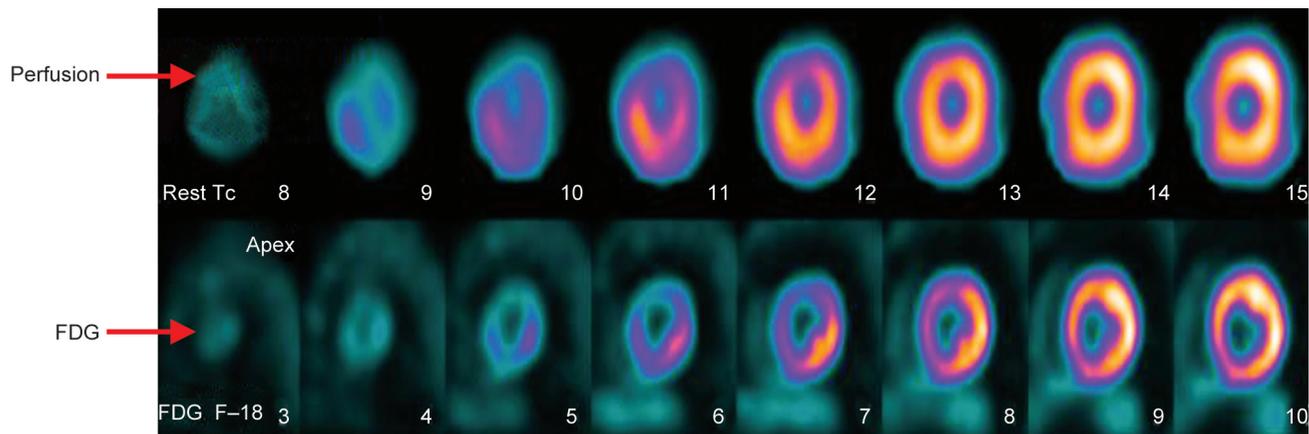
FDG PET depiction of nonviable myocardium in LAD territory (perfusion-metabolism match)
